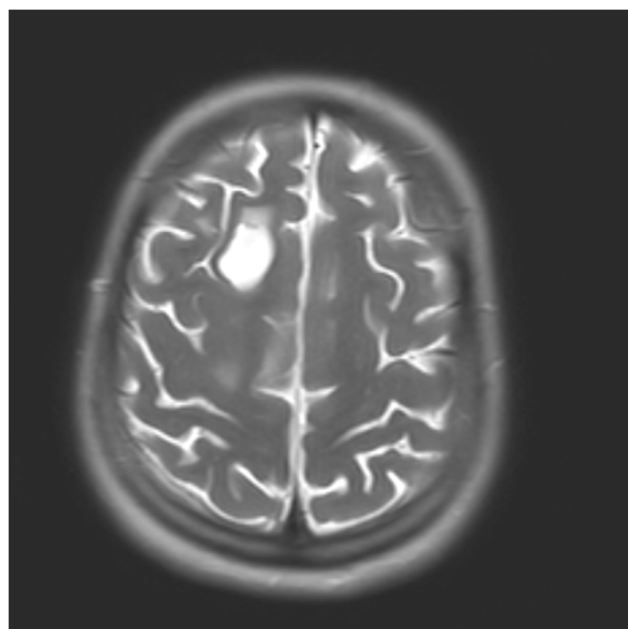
16-month follow-up imaging. Axial T2-weighted MRI of the brain demonstrating decreased PC and edema at 16 months
